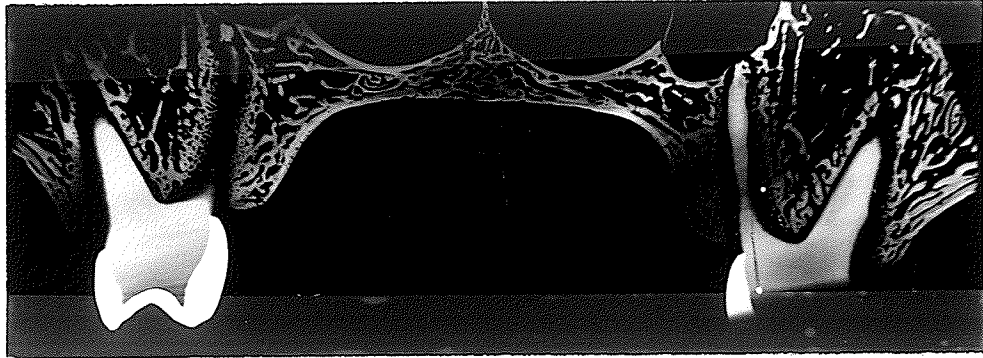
Soft x-ray radiograph of the midpalatal suture region, showing the normal sutural morphology. (X4)
